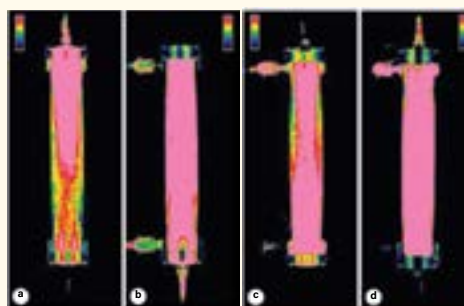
On the left, CT images acquired after reaching the total filling in the blood (a) and dialysate (c) compartment in the countercurrent flow experiment. Visible differences are noticed if compared with the same images acquired in the first experiment (b, d). The reduction of dye intensity in the images on the left is the consequence of the internal/backfiltration phenomenon that occurs in counter-current flow configuration. Figure adapted from Lorenzin, et al.
